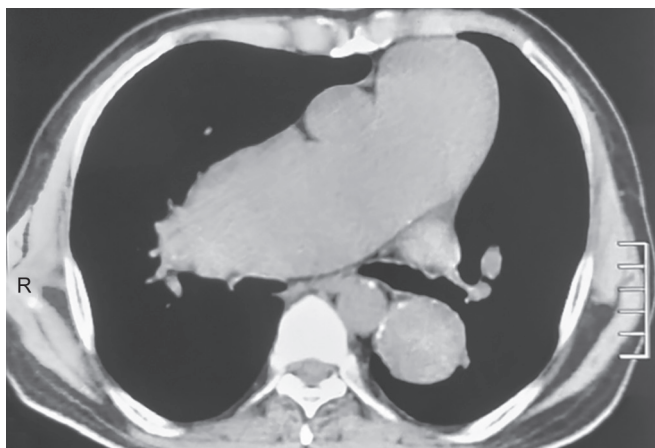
Axial CT image (mediastinal window) showing dilated pulmonary trunk
